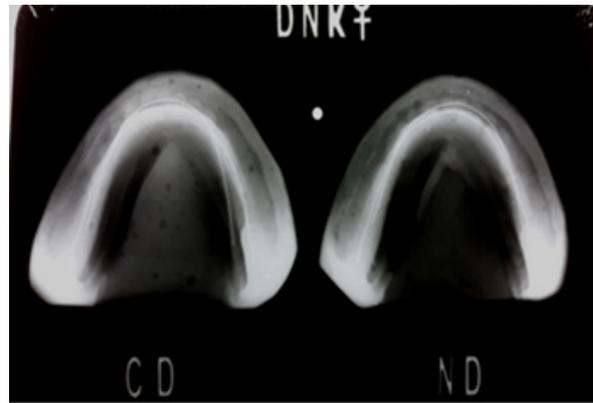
Radiographic assessment of tooth positions (relationship of the crest of the residual ridge to central fossae of the posterior teeth and lingual fossae of the anterior teeth)
